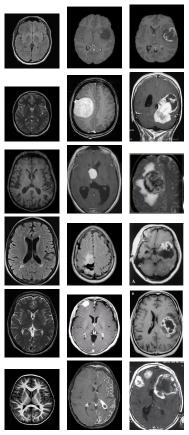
MRI Images of Healthy Brain, LGG and HGG
